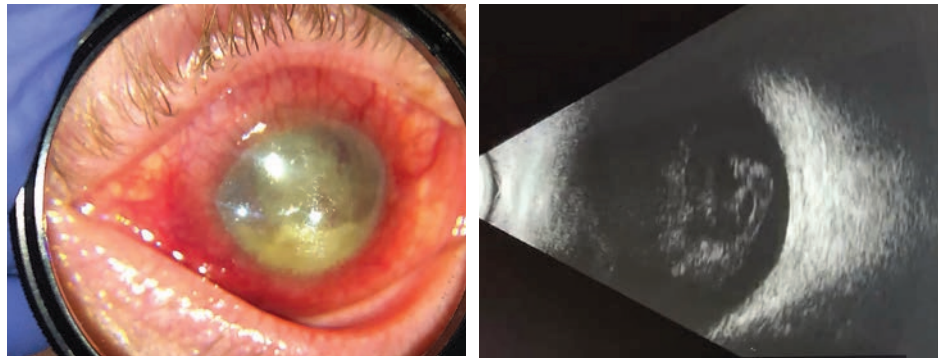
A) Corneal haze with layered hypopyon and prominent conjunctival injection and ciliary flush. B) Vitreous opacities on B-scan ultrasonography.
